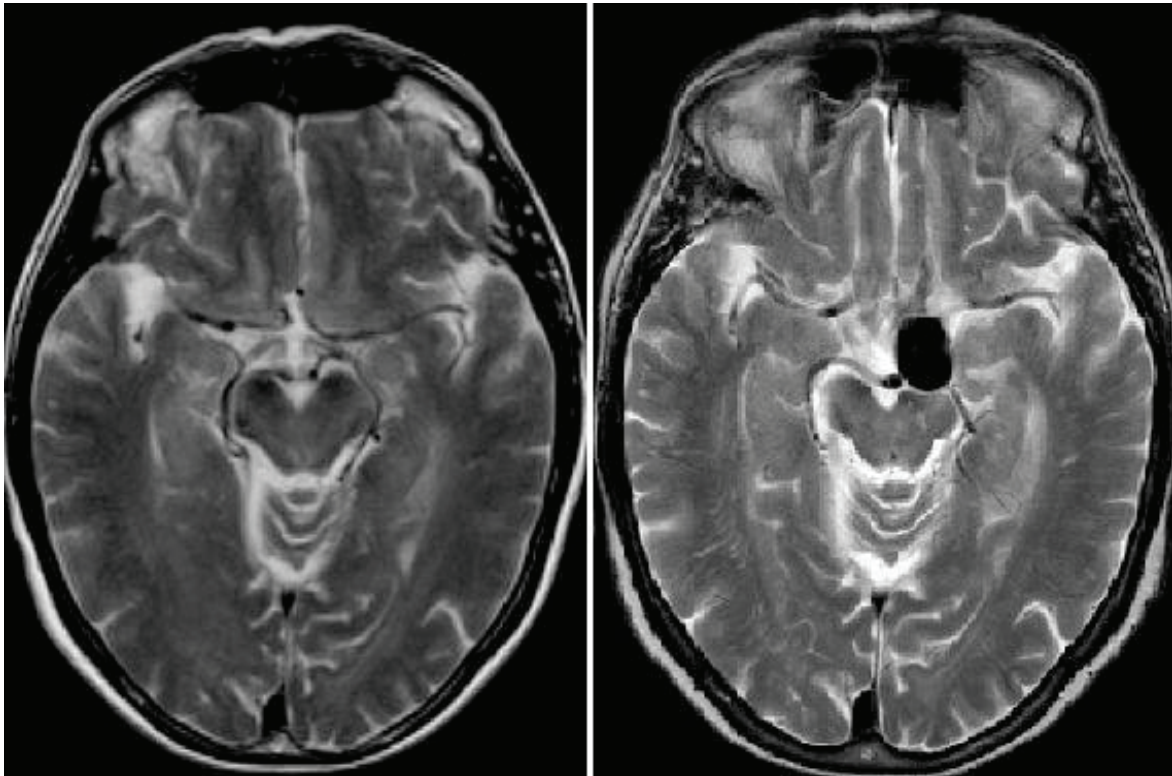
a) T2-weighted image in 2009. No presence of Aneurysm in the left carotid artery; b) T2-weighted image in 2017. Giant Aneurysm in the left carotid artery
